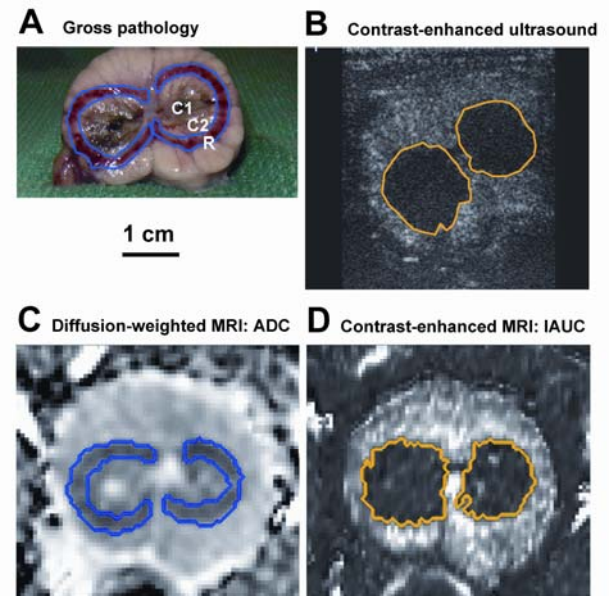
A: Gross pathology reveals 3 zones of thermal damage. B-D: Ultrasound and MRI (segmented regions in color).
